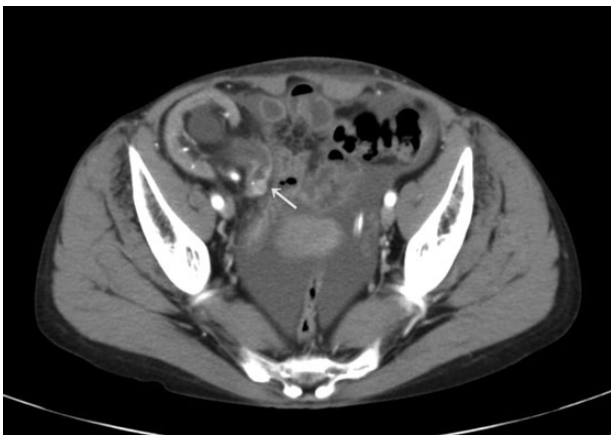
Computed tomography showed a thick wall at the pelvi-ureteral junction of the allograft kidney that had infiltrated adjacent fat tissue (arrow).
